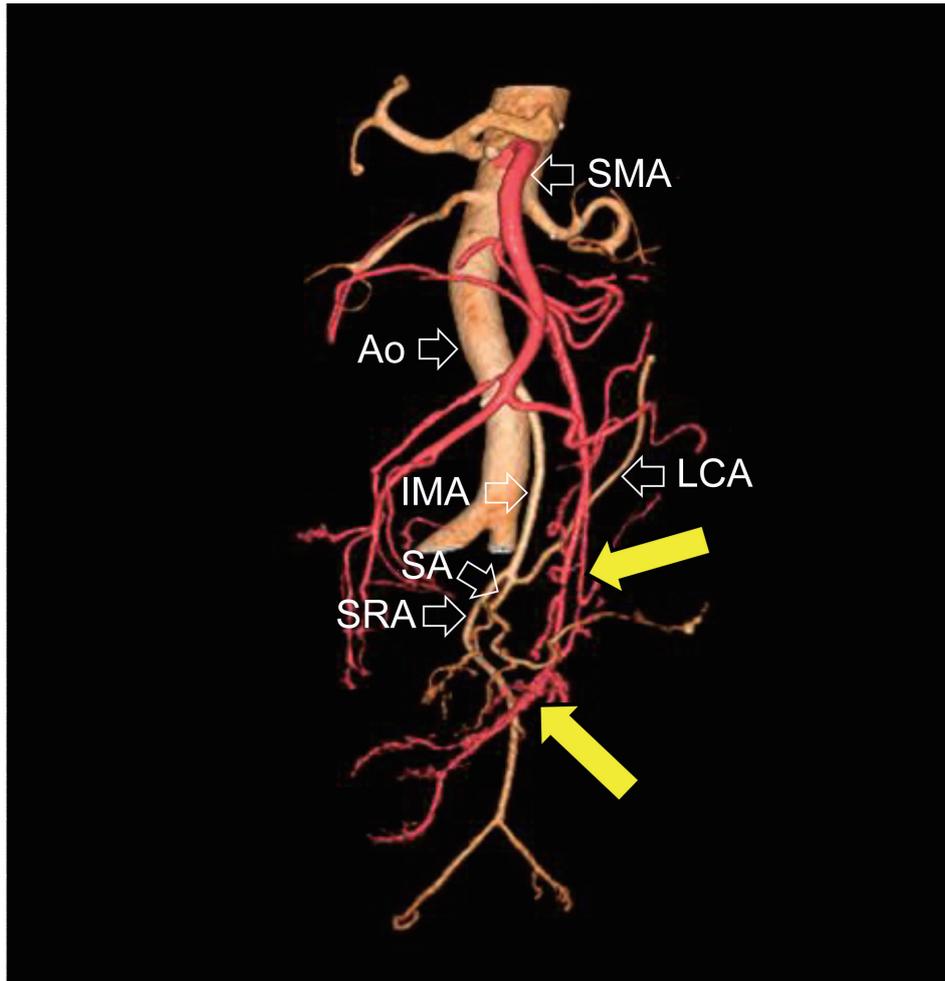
Selective volume-rendering three-dimensional computed tomography angiography image showing the mesenteric vessel of the herniated small-bowel running an abnormal course (yellow arrows). Notice that the mesenteric vessel of the herniated small-bowel runs dorsal to the sigmoid vessels. AO=abdominal aorta, SMA=superior mesenteric artery, IMA=inferior mesenteric artery, LCA=left colic artery, SA=sigmoid artery, and SRA=superior rectal artery.
